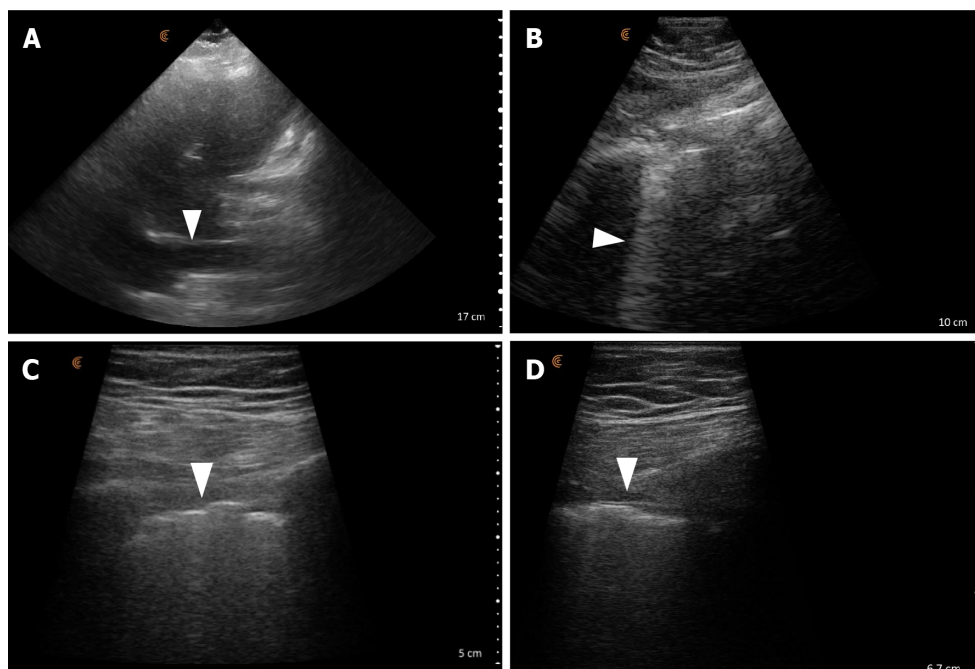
Point-of-care ultrasound findings favoring primary lung pathology over congestive heart failure. A: A relatively small IVC (< 1.5 cm maximal diameter); B: Confluent B-lines on lung ultrasound (arrowhead); C and D: Irregular pleural line imaged using a high frequency-low depth setting.
